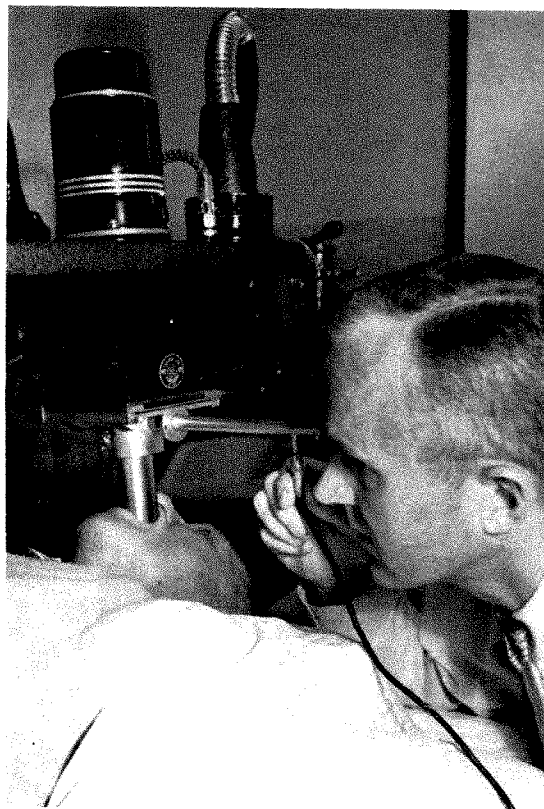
Low voltage (100 kv.) roentgen therapy. The position of the peroral cylinder is checked by the therapist using an electrically lighted periscope.
